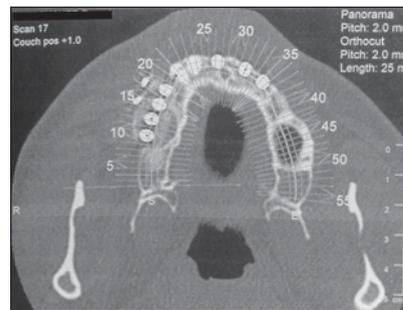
CT imaging after reconstruction with the prefabricated iliac flap. Complete restoration of the alveolar ridge was achieved. The dental arch was reconstructed as planned.
